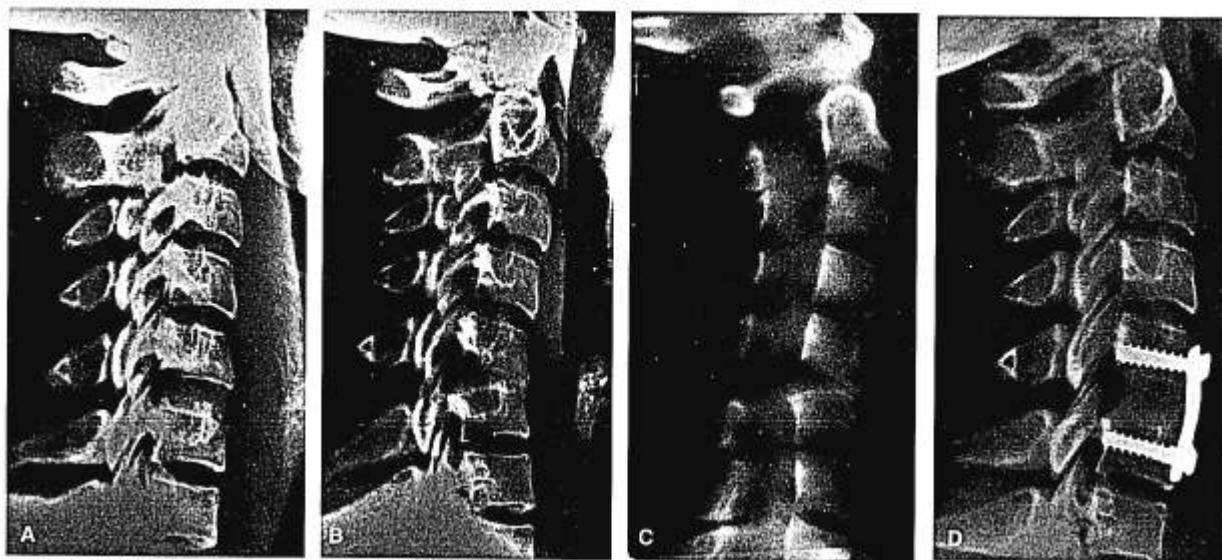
Initial postoperative lateral radiograph (A) following a C5-6 anterior cervical arthrodesis with iliac crest autograft without anterior cervical plate stabilization (ACPS). Six-month follow-up lateral cervical radiograph (B) and lateral tomogram (C) of same patient, demonstrating a collapse of the bone graft and resulting fusion of C5-6 in a flexion deformity of 18°. One year after the revision surgery at C5-6 for correction of the flexion deformity with ACPS (D).
